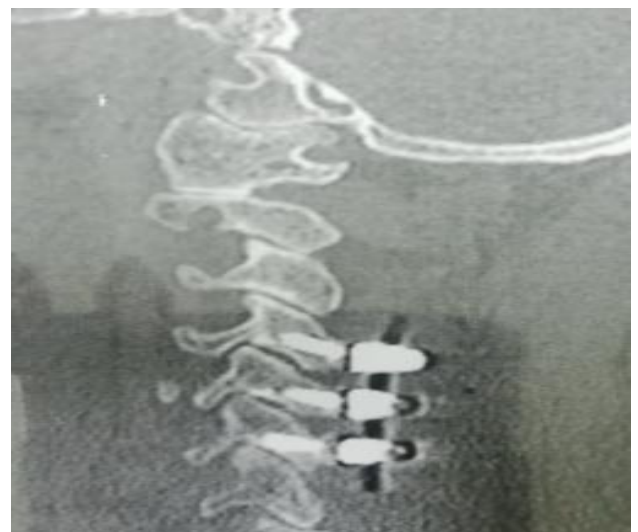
Postoperative CT cervical spine posterior coronal view showing lateral mass screws with the rod system associated with laminectomy to decompress cervical spine in 66 years old myelopathic female.
